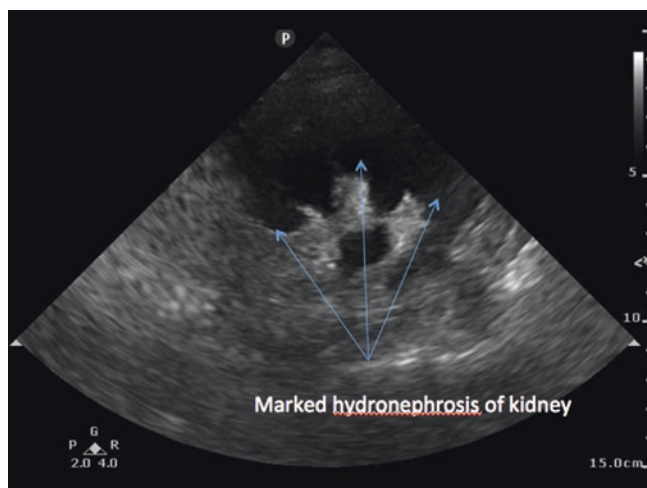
Bedside ultrasound for suspected renal disease. The longitudinal ultrasound of a left kidney shows a large hypoechoic (black) area in the center of the kidney extending into the parenchyma consistent with hydronephrosis. A similar finding was seen on the on the right side in this middle-aged male admitted with septic shock, acute renal failure, and gram-negative bacteremia. Bilateral nephrostomies were required which yielded purulent urine. See also Video 37.13
